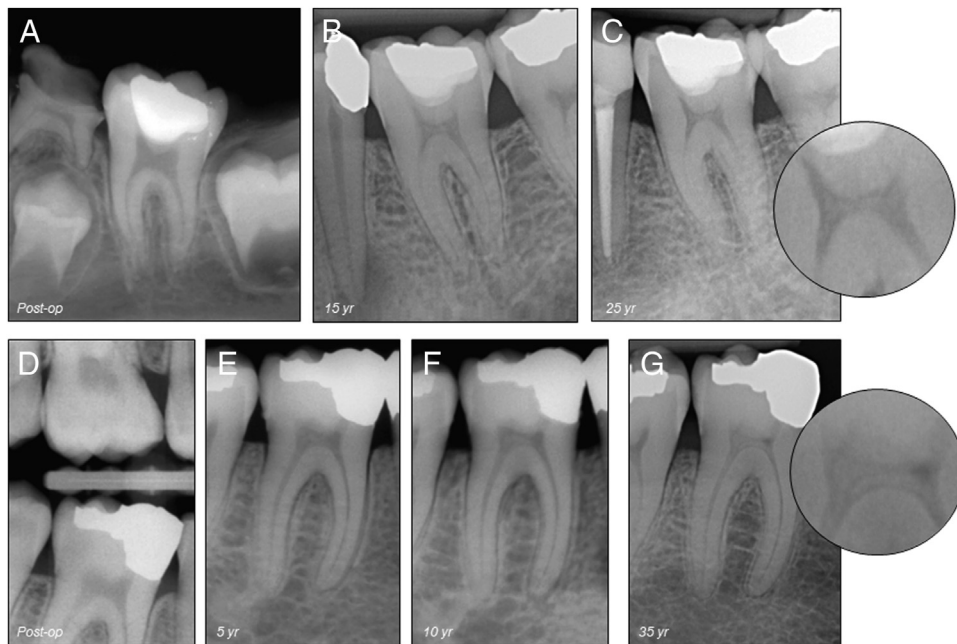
(A) Tooth #19 with deep occlusal caries in a 9-year-old girl. Medium exposure of the mesiolingual pulp horns. Bleeding time < 3 minutes. Capping with calcium hydroxide powder. Dycal and zinc phosphate cement were applied and the cavity restored with amalgam. Postoperative radiograph. (B–C). Follow-up radiographs taken respectively after 15 and 25 years. The case was assessed as success. The pulp responded normally to sensibility tests. Normal periapical conditions. Reduction of the pulp space. Barely distinguishable calcifications in the pulp space (magnified circle). Note that pulp stones are present in the chamber of the neighboring tooth #18. (D) Tooth #30 with deep mesio-occlusal caries in a 12-year-old girl. Medium exposure of mesiobuccal pulp horns. Bleeding time <3 minutes. Capping with calcium hydroxide powder. Dycal and zinc phosphate cement applied and cavity restored with amalgam. Postoperative bite-wing radiograph. (E–G) Follow-up radiographs taken respectively after 5, 10, and 35 years. The case was assessed as success. The pulp responded normally to sensibility tests. Normal periapical conditions. General reduction of the pulp space. Progressive formation of calcified masses occupying large part of the pulp chamber volume in the last follow-up radiograph (magnified circle).
